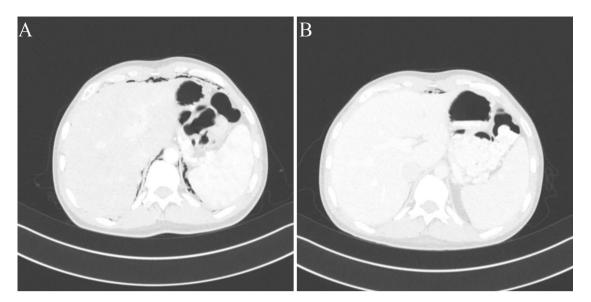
CT scan showing pneumoretroperitoneum — at diagnosis (A) and (B) before discharge
